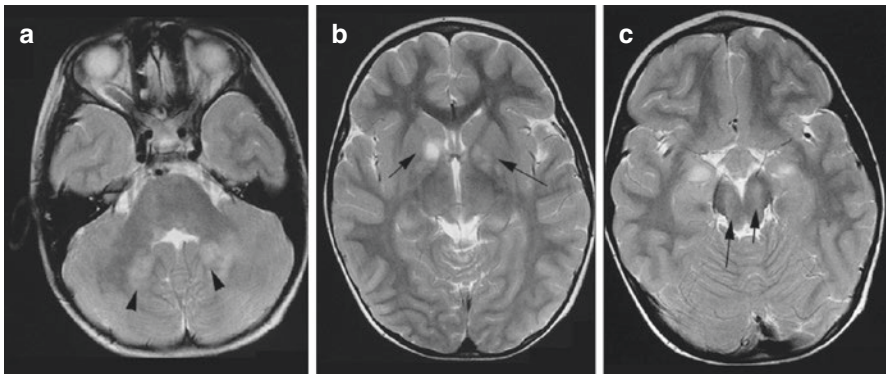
A 5-year-old boy with NF1; (a) axial T2-weighted MRI demonstrates typical high signal areas in the deep white matter of the cerebellum; (b) bilateral high signal foci in the globus pallidus, and (c) in the cerebral peduncles (arrows)
